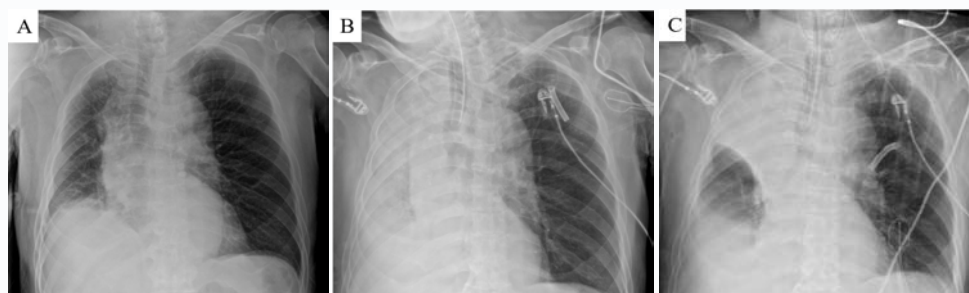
The patient's chest radiograph finding. (A) Preoperative chest X-ray taken at emergency room. (B) After induction, when the patient presented hypoxemia. (C) After massive suction was done.
